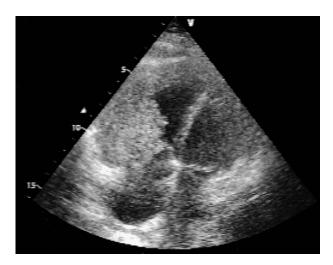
Transthoracic echocardiogram showing right ventricular mass occupying most of the cavity.
